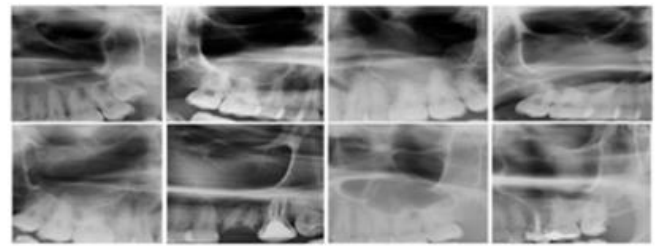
Sections of cropped panoramic radiographs show examples of maxillary sinus abnormalities. A. Normal. B. Mucosal thickening. C. Sinus polyp. D. Antral pseudocyst. E. Non-specific opacification. F. Periostitis. G. Antrolith. H.
